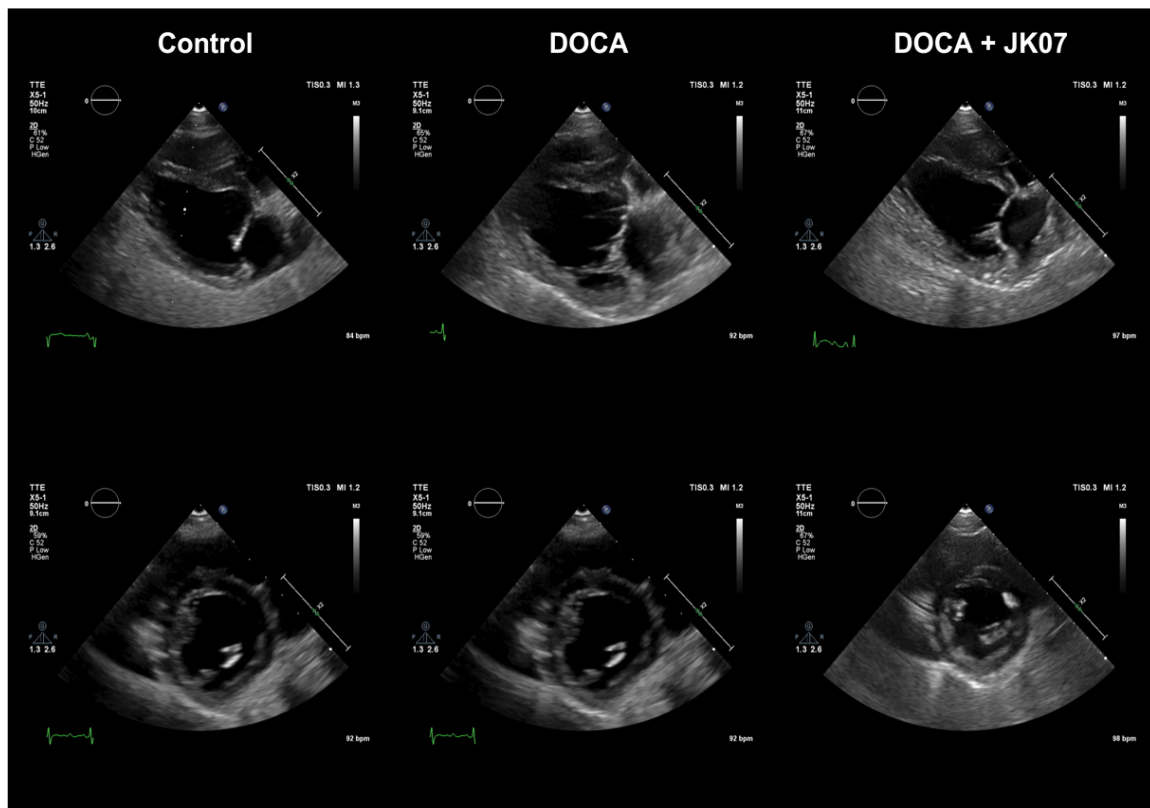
Representative ultrasound images of each group in parasternal long axis-like (upper) and parasternal short axis-like (lower) views.*
